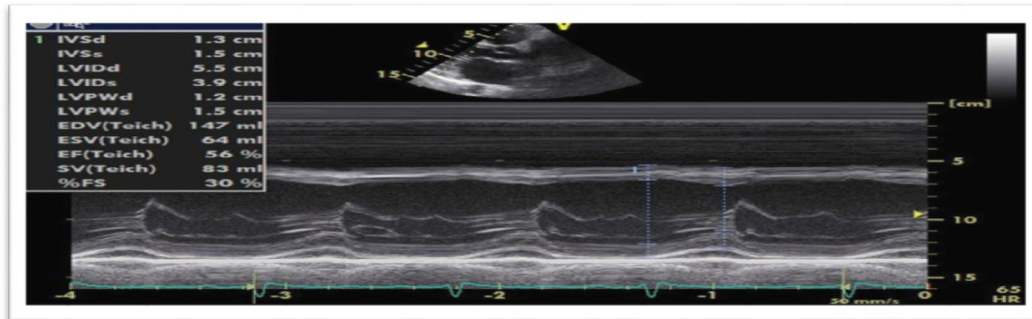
Measurement of LV systolic function by M-mode in the parasternal long view
